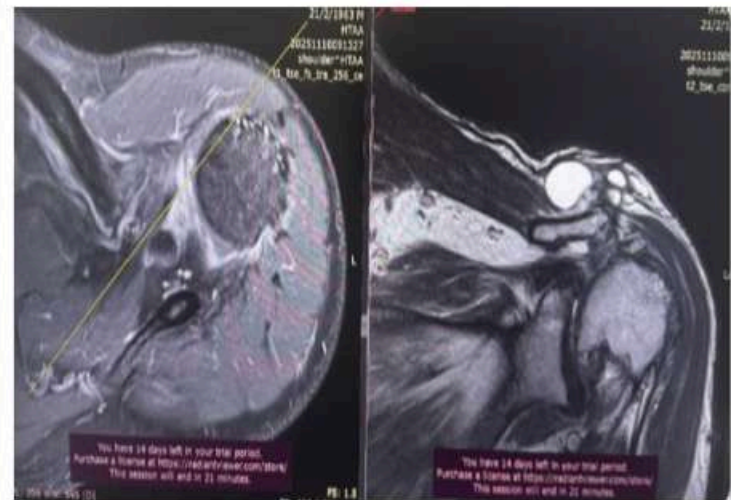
MRI left shoulder
